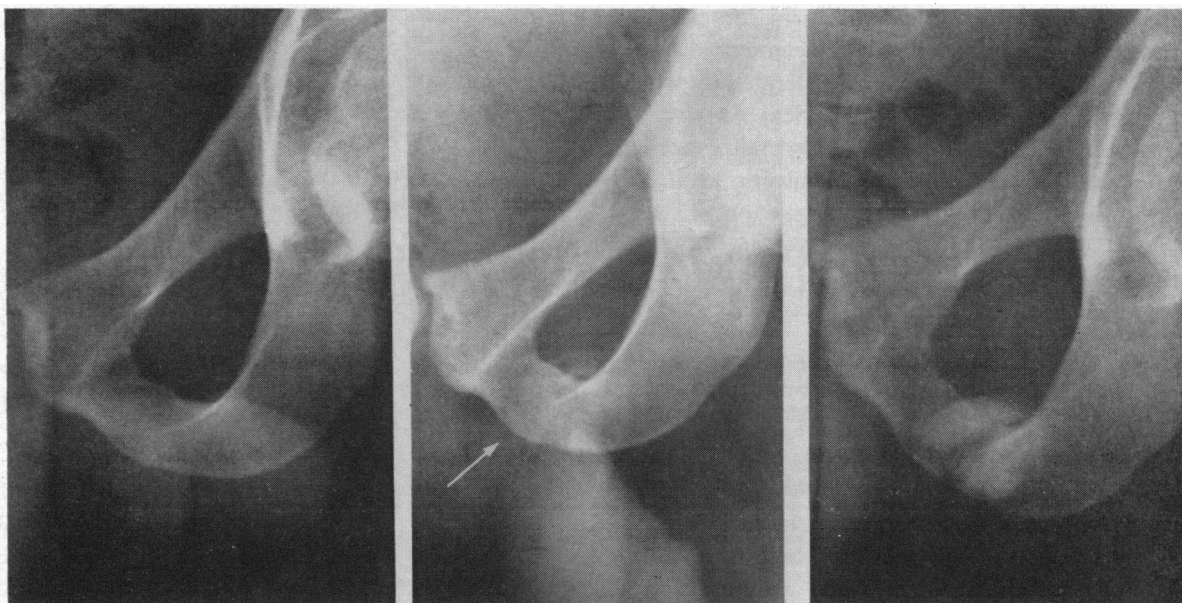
Typical progression of a fatigue fracture of the ischiopubic ramus. X-ray films were taken one and a half weeks, three and a half weeks and eight weeks after onset of symptoms. Initial film appears normal; progressive formation of callus is seen in second and third.
